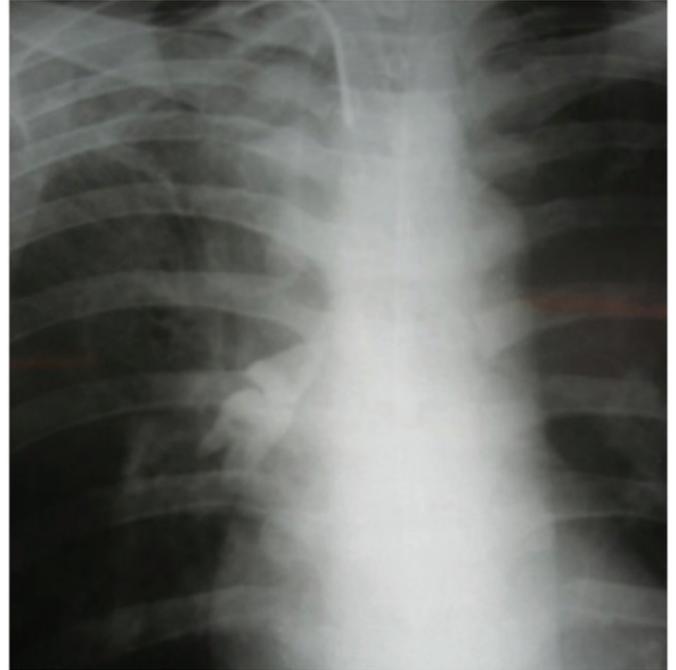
Subsequent radiograph showed both teeth were in the right bronchus
